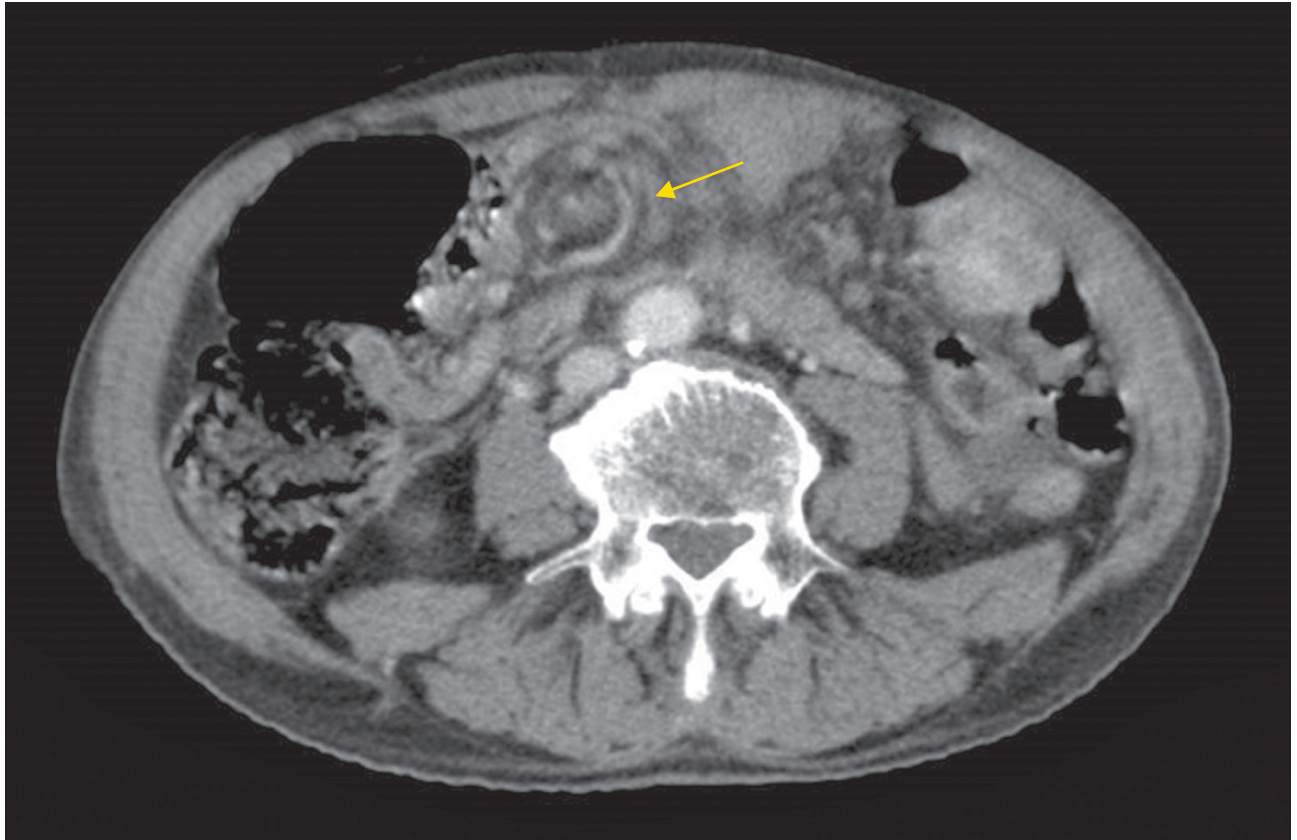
Abdominal CT scan, axial. Arrow: whirlpool sign, suggestive of mesenteric torsion.
